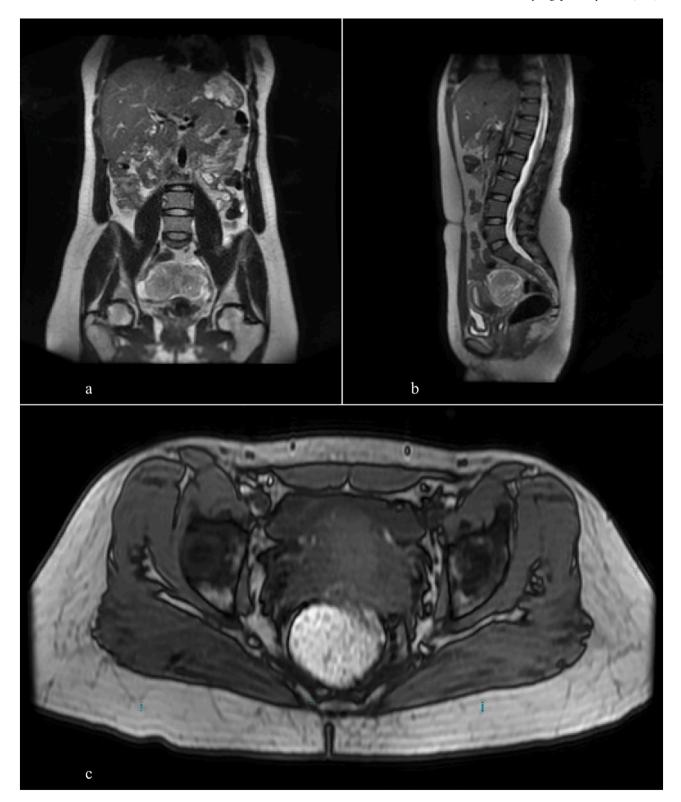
Magnetic resonance imaging (MRI) demonstrating a 9 cm extrauterine T2 hyperintense, T1 hypointense, diffusion restricting solid appearing mass centered in the posterior cul-de-sac of the pelvis A: Coronal view B: Sagittal view C: Axial view.
